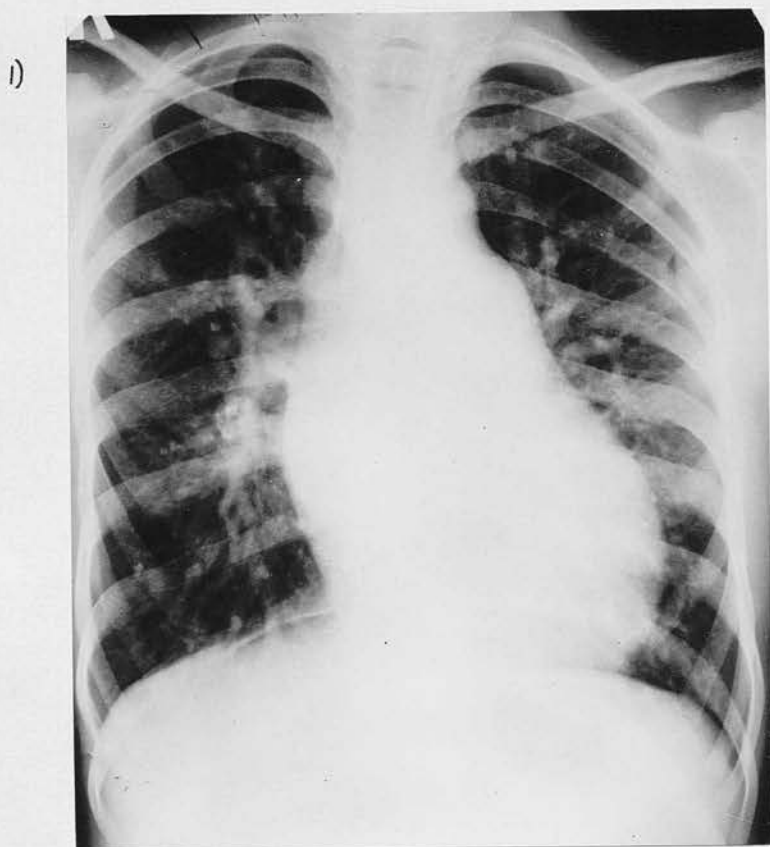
Radiograph of Case 45. Stomal Ductus, with recanalisation after ligation.
